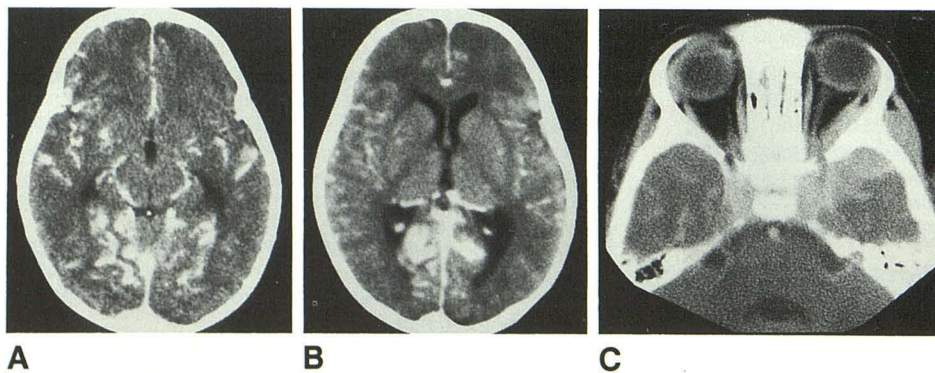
A–C, Contrast-enhanced cranial CT scans obtained at time of symptoms show sulcal and cisternal enhancement (A and B), especially about sylvian fissures and tentorium, and an enhancing soft-tissue mass (C) with epicenter about lateral aspect of left sphenoid bone extending into temporal fossa, floor of middle cranial fossa, and medial extraconal space.
